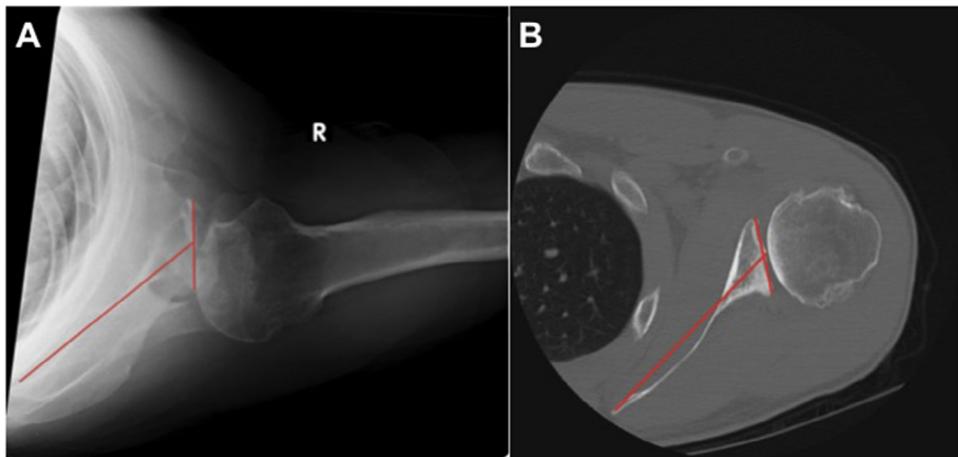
Preoperative axillary radiograph (A) and computed tomography scan (B) used for measurement of glenoid retroversion. “R” indicates right shoulder.
